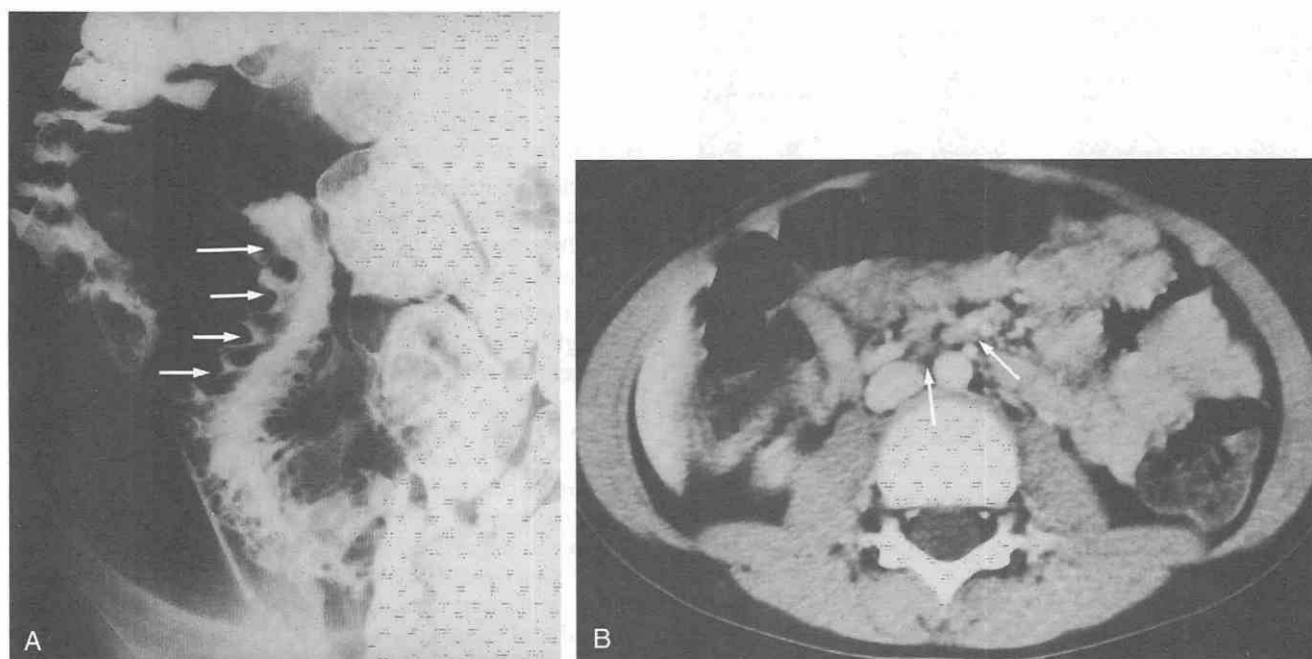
Yersiniosis. *A*, Small-bowel follow-through scan shows multiple nodular defects (arrows) in the distal ileum. *B*, CT scan shows minimal mesenteric lymphadenopathy (arrows).
